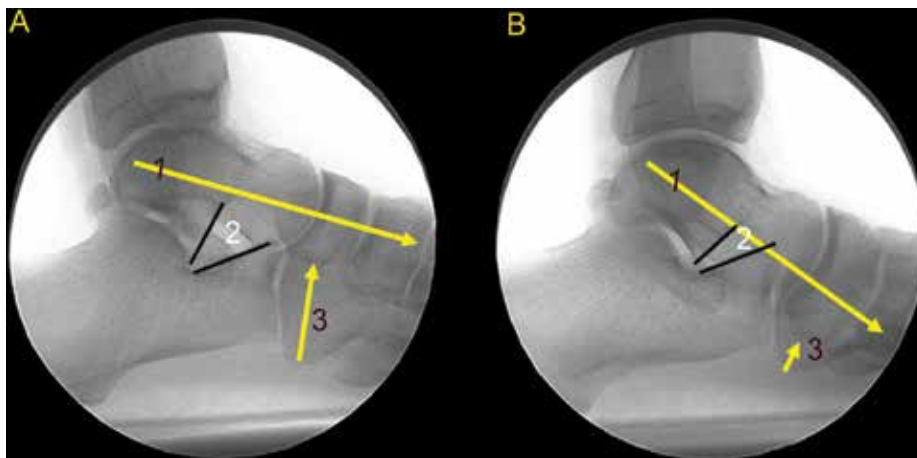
Weightbearing lateral radiograph of the same patient’s foot. A. Patient’s TTJ is in neutral position. (A1) Talar bisection is within normal limits. (A2) The open sinus tarsi space. (A3) Normal navicular height. (B1) Abnormal plantar flexions of the talus. (B2) Abnormal partial obliteration of the sinus tarsi. (B3) Shows a pathologic lowering of the navicular.
